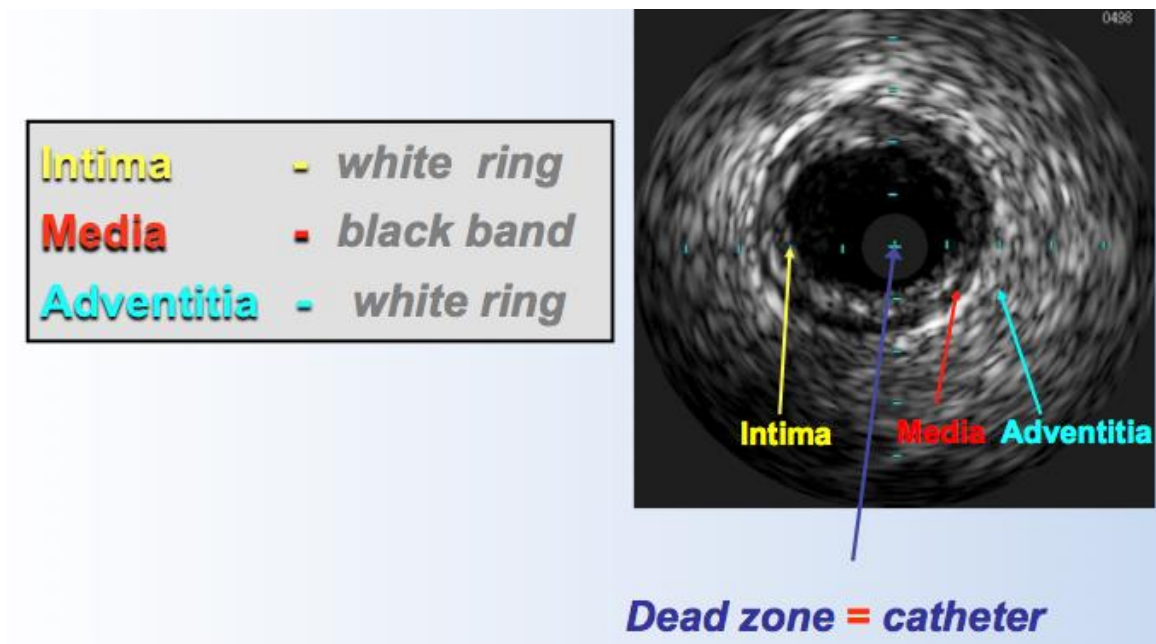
Intravascular ultrasound : arterial layers description
